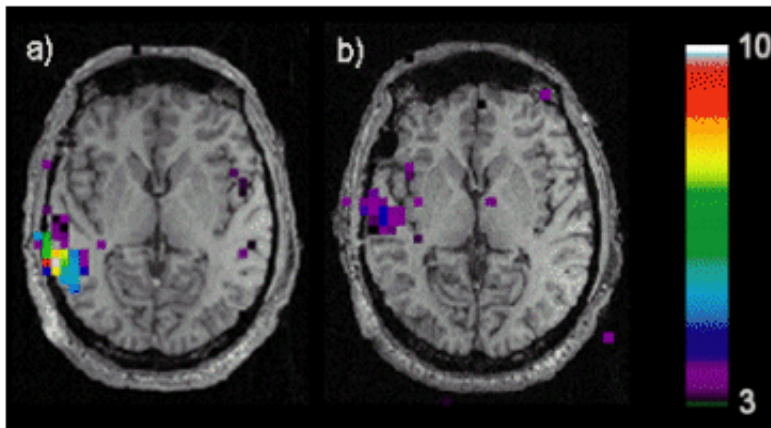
Functional MRI activations from two scans of the same patient a) scan 1, the HRF assumed in the analysis was a single gamma function peaking at 5.4 seconds and b) scan 2, the peak of the HRF was at 9 seconds.
